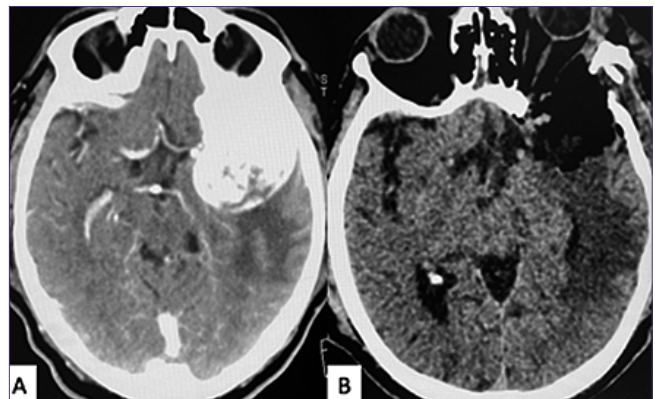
Axial computed tomography studies in a patient with a right sphenoid wing meningioma, before and after resection using a transorbital microsurgical approach (TOMS). A: Preoperative contrast-enhanced image demonstrating an extra-axial lesion. Hyperdense with homogeneous enhancement, located in the region of the right sphenoid wing, with orbitocranial extension and adjacent hyperostosis. A mass effect is observed over the temporal pole and superior orbital displacement; B: Immediate postoperative image without contrast shows complete resection of the lesion and is associated with complete decompression of the optic canal and the orbitotemporal wall.
